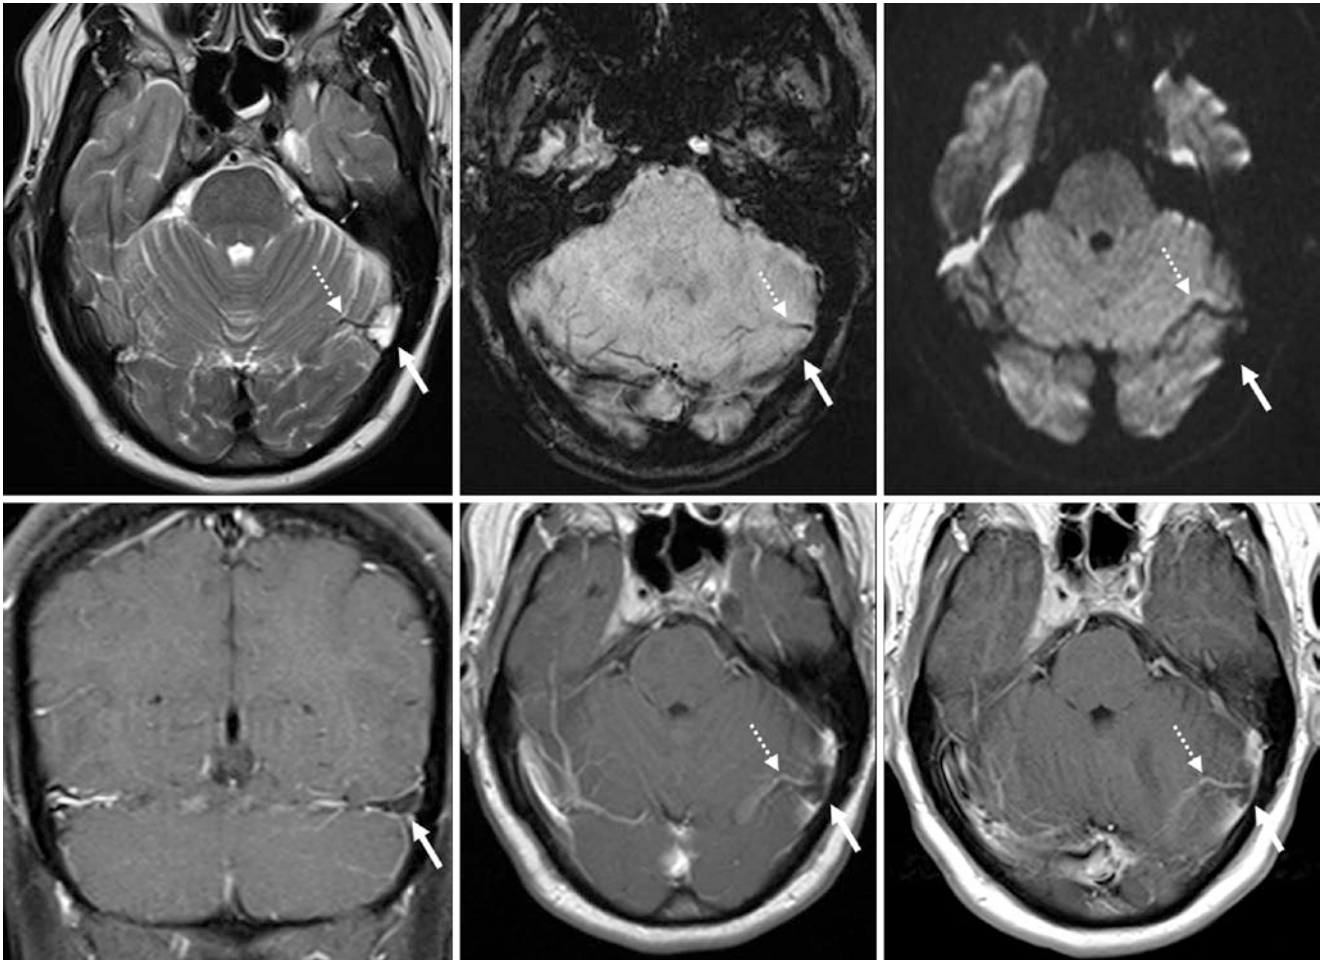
Top row:* 37-year-old with a normal arachnoid granulation (arrows) that filled most of the LTS on a 1.5 T MRI. The granulation was bright akin to CSF on T2WI (left), was imperceptible on SWI (middle), and was dark on DWI (right), and FLAIR (not shown). *Bottom*
